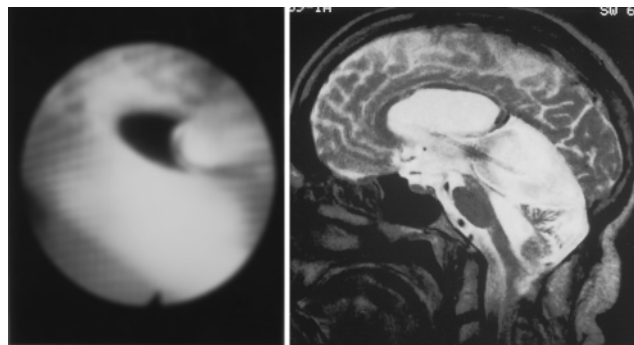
Left:* Endoscopic view. The apparently patent ventriculocystostomy is actually occluded by a transparent membrane, which is bluntly perforated with a Fogarty catheter. *Right:* Post-operative T₂-weighted midsagittal MR images demonstrating good stent positioning. The heterogeneous signal from the cyst content suggests flow within the cavity.
